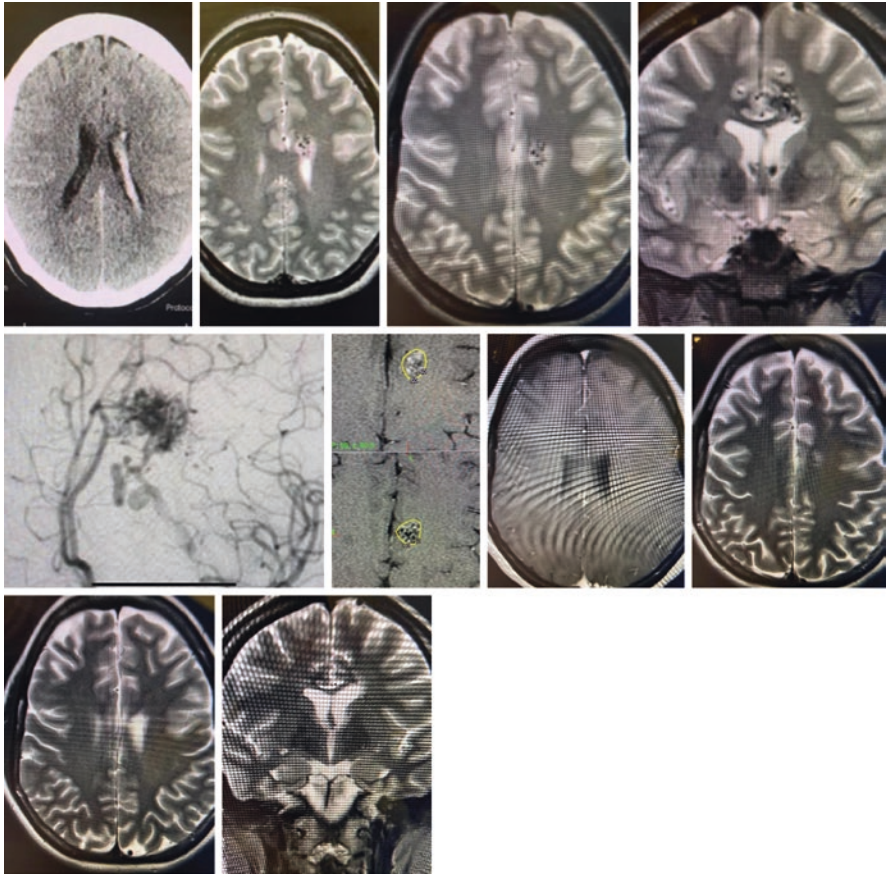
This is a 25-year-old woman who presented with a sudden severe headache found to have an acute left intraventricular hemorrhage (a: axial CT image). MRI demonstrated a deep left frontal AVM extending into the left lateral ventricle (b, c: axial T2 weighted MRI; d: coronal T2 weighted MRI; e: lateral cerebral left carotid angiogram). The patient fully recovered from the bleed and subsequently underwent Gamma Knife treatment (f: axial T1 postcontrast images from the day of Gamma Knife treatment). MRI images 1.5 years after treatment show the AVM is gone (g: T1 postcontrast axial MRI; h, i: T2 weighted axial MRI; j: coronal T2 weighted MRI)
